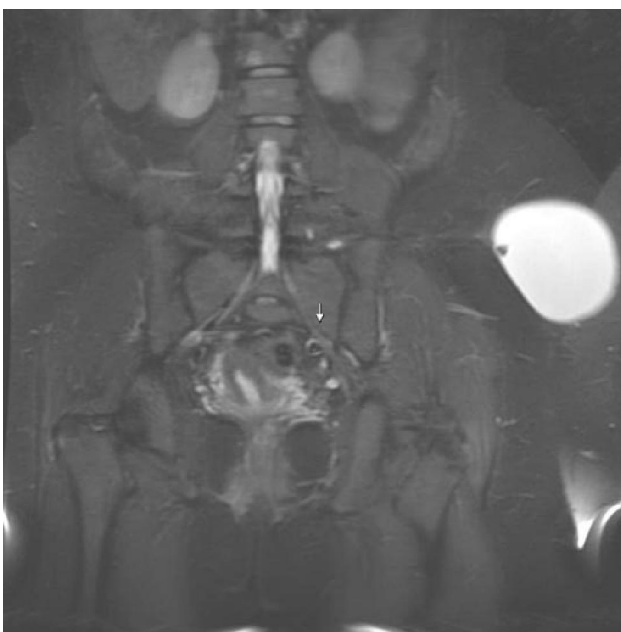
(c): MRI COR STIR, showing signal loss of focus of fat.
